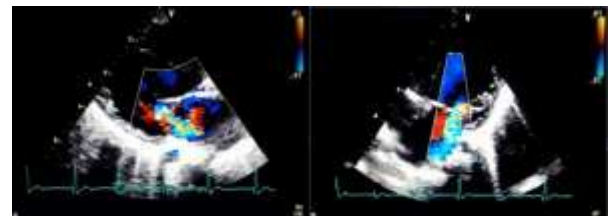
Severe chronic mitral regurgitation (MR) on follow-up after 8 months interval; A: Parasternal long axis view, B: Apical 4 chamber view
